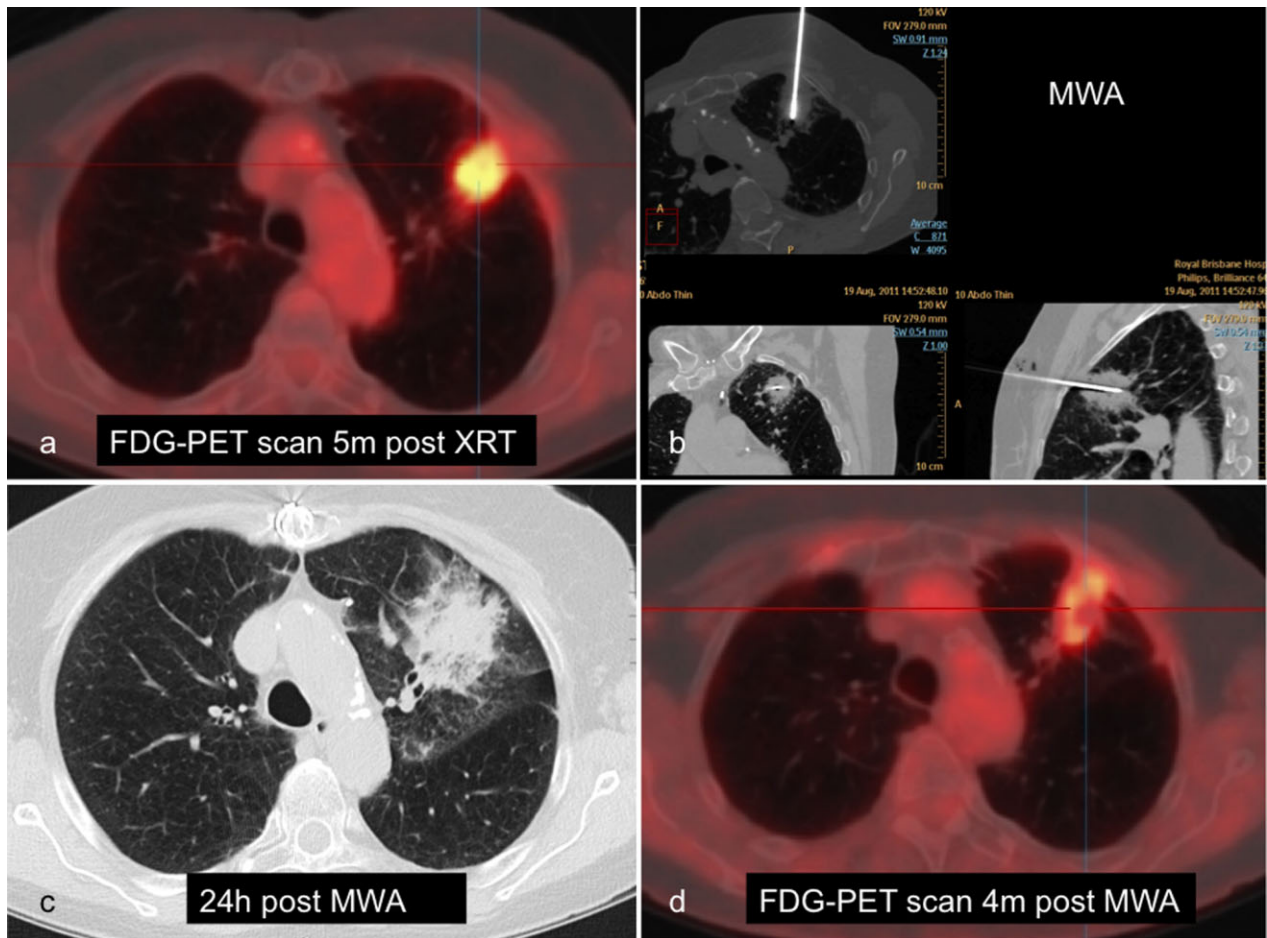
Seventy-five-year-old female post-radical external beam radiation (XRT) for left upper lobe T1N0M0 non-small cell lung cancer (NSCLC): (a) fludeoxyglucose (FDG)-positron emission tomography (PET) scan 5 months post-conclusion of XRT shows residual local tumour avidity; (b) microwave ablation (MWA), multiplanar reformats show central position of the antenna within the tumour; (c) axial CT scan lung window 24 hours post-MWA shows the ablated tumour surrounded by ground glass opacity (GGO); (d) FDG-PET scan 4 months post-MWA shows residual ring-like uptake, reported as residual/recurrent local disease.
